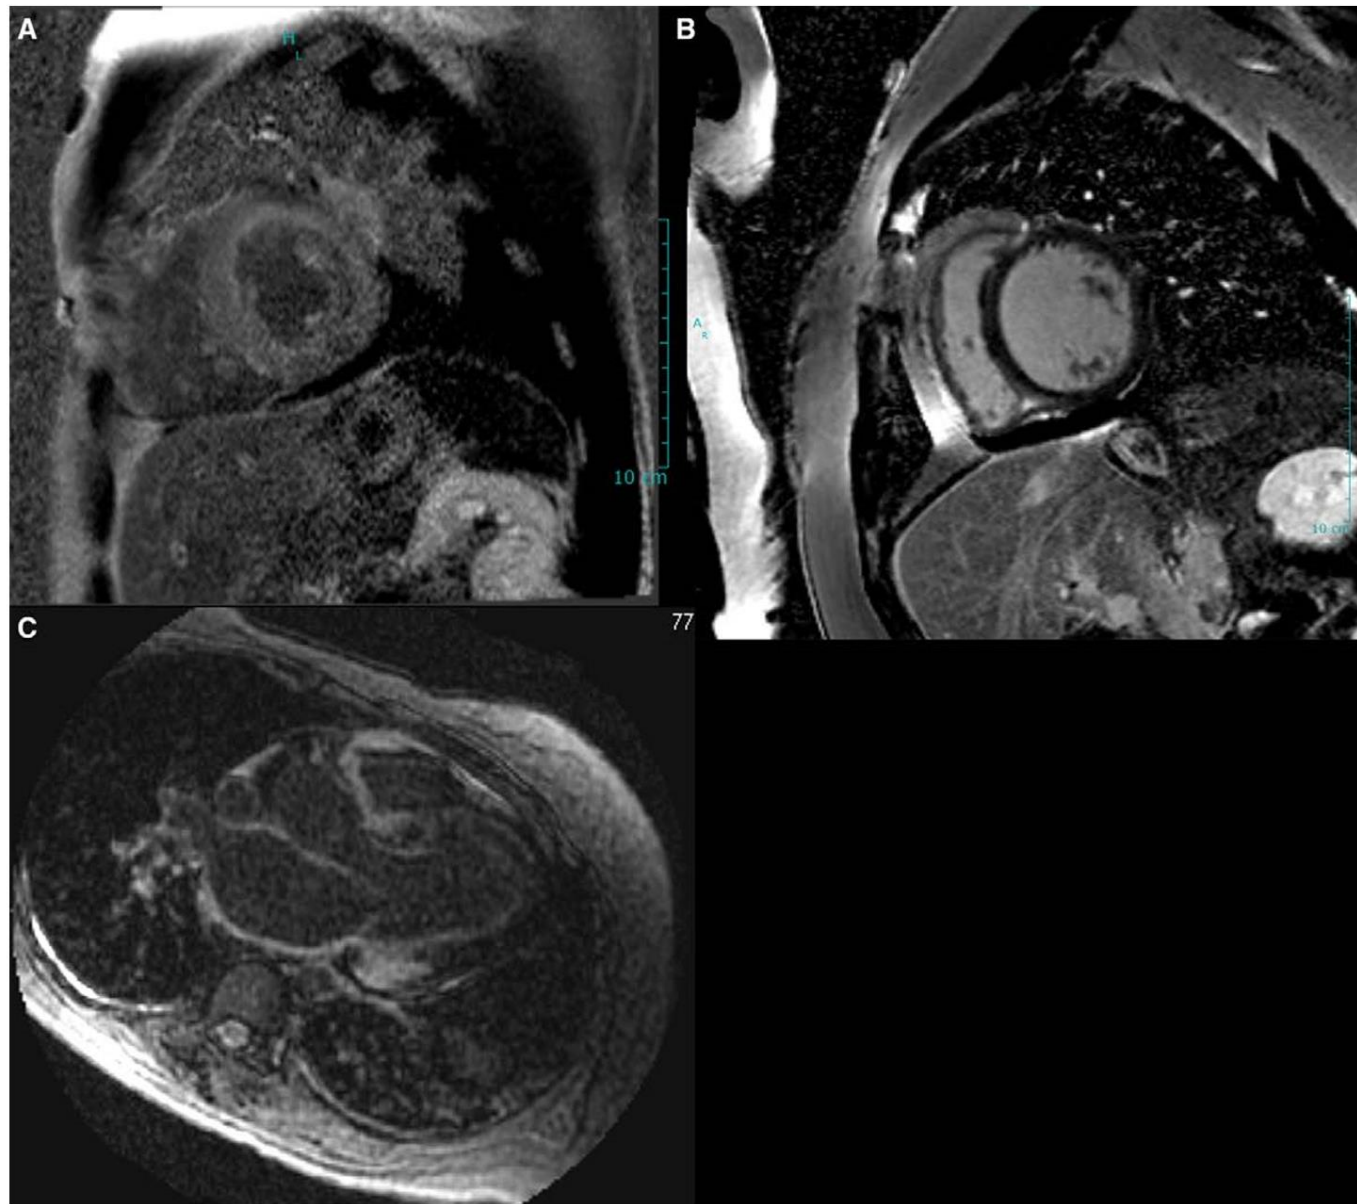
Typical rest cardiac magnetic resonance imaging features in a patient with familial transthyretin cardiac amyloidosis. Late gadolinium enhancement (LGE) images demonstrate diffuse LGE in the left ventricular myocardium (A) contrasted with dark myocardium in a normal patient (B). C, LGE in the atrial wall, a characteristic feature of cardiac amyloidosis.
